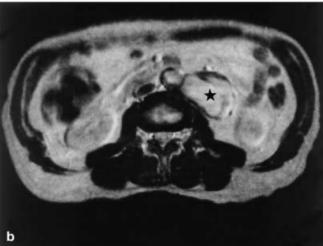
A 61-year-old man (patient 3) T2-weighted images (TR = 2400 ms, TE = 80 and 140 ms, respectively) shows a well-delimited latero-aortic tumor presenting an increased signal intensity (H)
